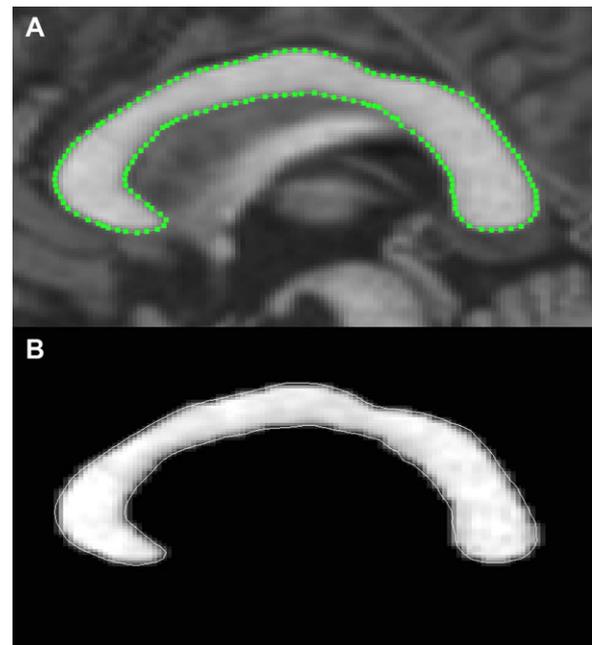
Corpus callosum area determination from 3-D T1-weighted MDEFT images obtained with 3T MRI. (A) Using a semiautomated edge detection method, an ROI is created for the midline of the corpus callosum. (B) The corpus callosum is visualized as a masked view for cross sectional area determination.
